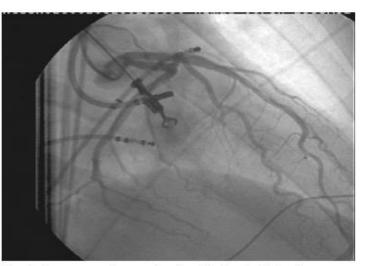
Coronary angiogram showing injection to left main coronary artery (RAO projection). Point at the ostium of left main coronary artery was acquired by the ablation catheter. This point was used for point-based registration of CT image and electroanatomic map
